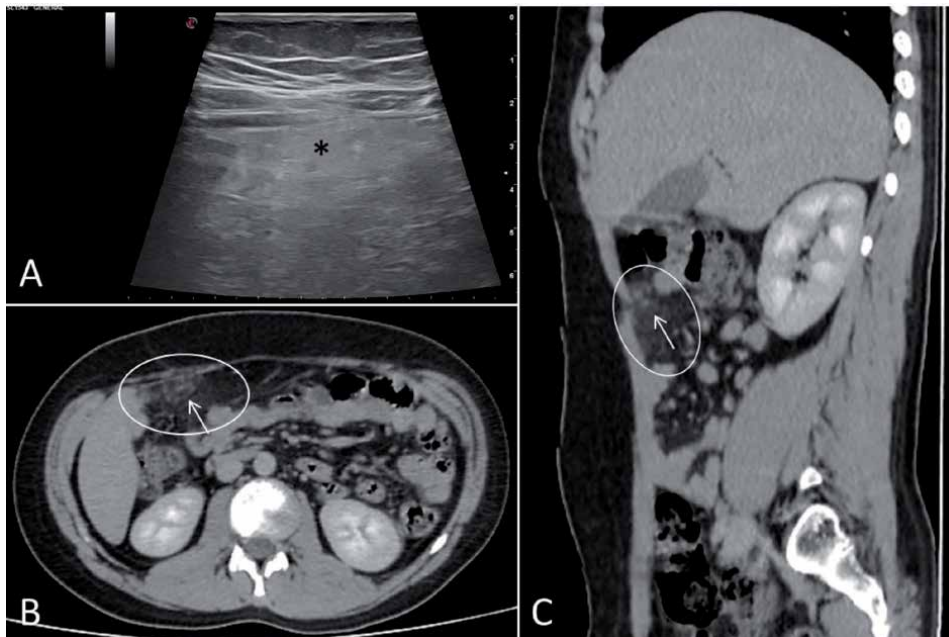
Ultrasound image (A) of an 11-year-old boy demonstrates thickened hyperechoic mass (asterisk) with indistinct border beneath the anterior abdominal wall. Intravenous contrast enhanced axial CT (B) and sagittal reconstructed image (C) shows hyperdense omentum (white circles), hyperdense dot at the center of lesion (arrows). The dot can be followed on the contiguous images as a linear tortuous hyperdense structure consistent with twisted vein. Surgical removal of necrotic tissue confirmed the diagnosis of omental infarct.
